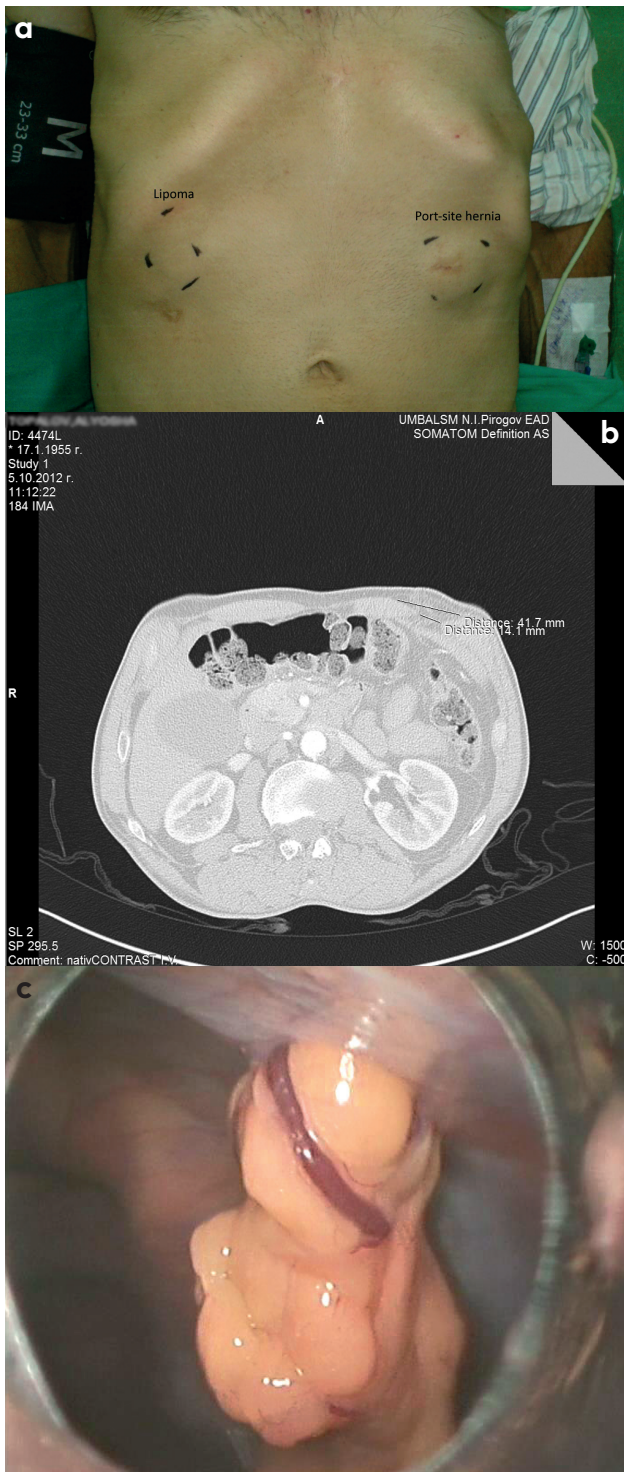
(a) Follow-up visit at 25 month. Postoperative port (drain) site hernia. (b) Follow-up visit at 25 month. CT scan demonstrating a port (drain) site hernia containing omentum. (c) Laparoscopic view of the postoperative drain site hernia containing omentum.
